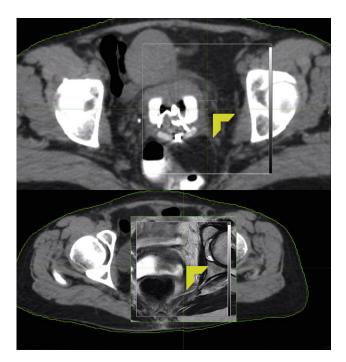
Visual depiction of the local alignment point selected for image deformation. The *superior arrow* points to the reference point selected on the planning CT, and the *inferior arrow* demonstrates the corresponding point on the registered MRI. The point is near the periphery of the cervix, adjacent to the parametrium. Additionally, the sidewalls of the upper vagina were optimal reference points as a result of the visibility of the vagina on MRI and CT secondary to aqueous vaginal gel and radio-opaque packing, respectively.
